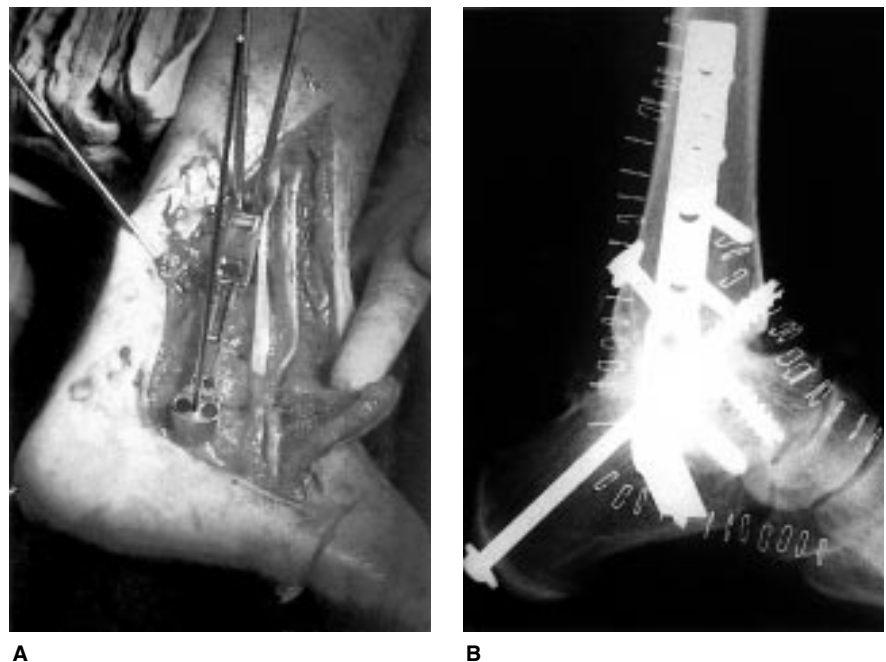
A, Intraoperative lateral view of a tibiototalcalcaneal arthrodesis with placement of a 90-degree blade-plate guide and large cancellous-screw guide pins prior to blade-plate impaction. B, Lateral radiograph obtained after insertion of lateral blade-plate.
